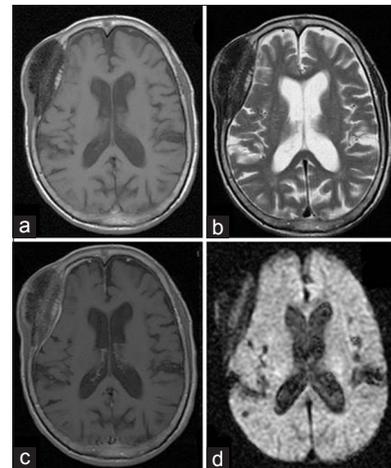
Axial T1- (a) and T2-weighted (b) Magnetic resonance imaging (MRI) showing heterogeneous iso - to hypointense lesion of the right frontoparietal bone. Gadolinium-enhanced MRI (c) Showing no enhancement of the lesion. Diffusion weighted image (d) Showing heterogeneous isointense of the lesion
